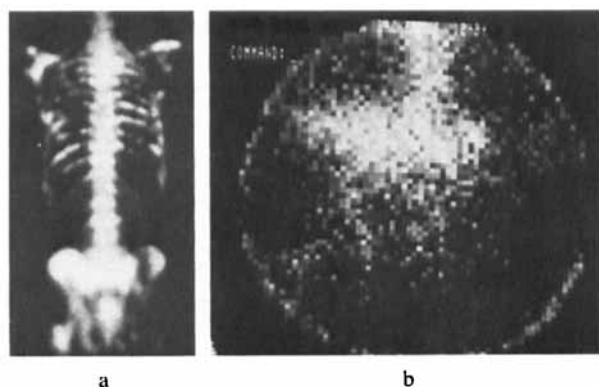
Comparison between <sup>99</sup>Tc<sup>m</sup> MDP bone scintigram (a) prior to therapy and <sup>89</sup>Sr 'Brehmsstrahlung' scintigram and (b) concerning the most painful sites, viz. pelvis and lower spine (posterior views). The <sup>89</sup>Sr scanning was made 4 weeks after the first injection of <sup>89</sup>Sr.
